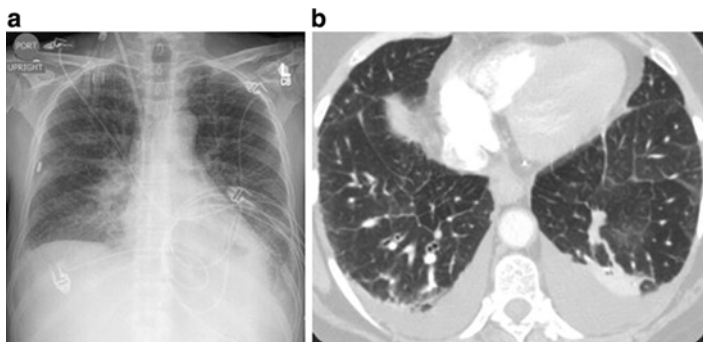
Pulmonary edema. (a) AP chest radiograph shows pulmonary vascular indistinctness, diffuse opacification, and septal thickening. Blunting of the costophrenic angles indicates bilateral pleural effusions. (b) Axial CT image through the lower lobes, demonstrating interlobular septal thickening, ground-glass opacities, and small bilateral pleural effusions (Reprinted from Bentz and Primack [11], with permission from Elsevier)
